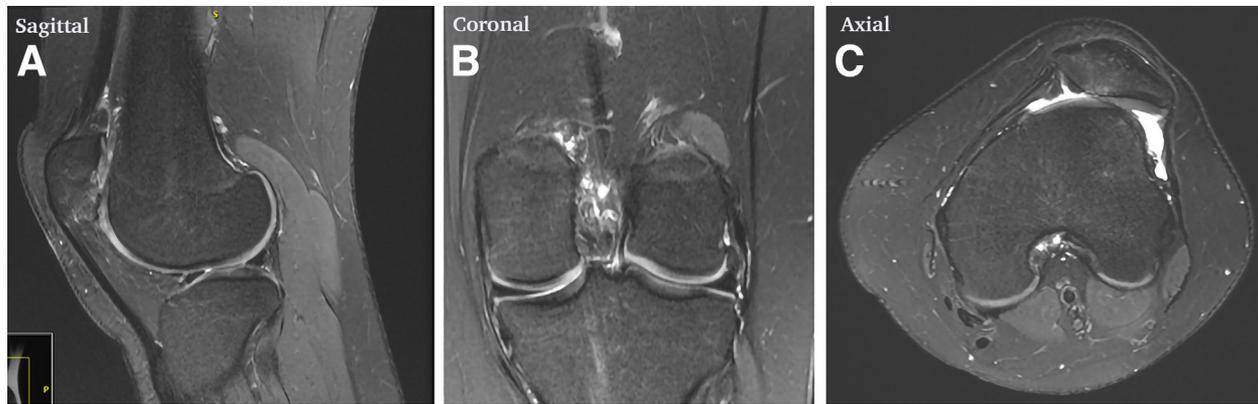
MRI from a 23-year-old female patient with patellofemoral instability showing sagittal (A), coronal (B), and axial views (C) of knee cartilage thickness of 3 mm with a displaced patella.
